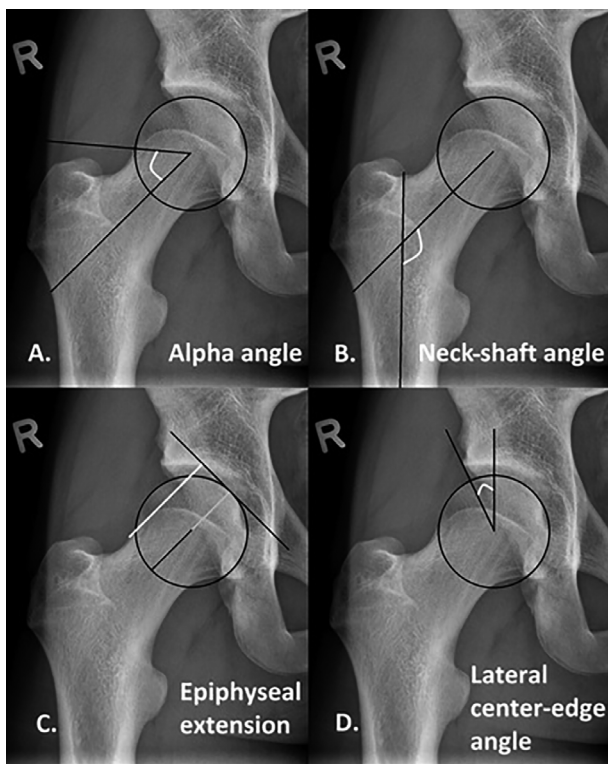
The radiographic measurements of the same right hip.
